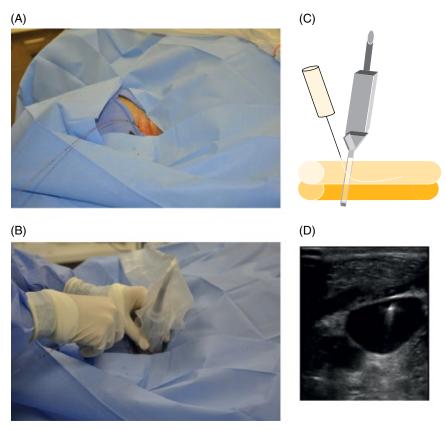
Ultrasound of the guidewire. (A) Following cannulation of the vein the guidewire is passed through the introducer needle and the needle is removed. (B) The ultrasound is again placed at the insertion site to visualize the guidewire (C) and confirm that the guidewire is in the vein and *not* in the artery (D) before dilation of the vessel is performed.
